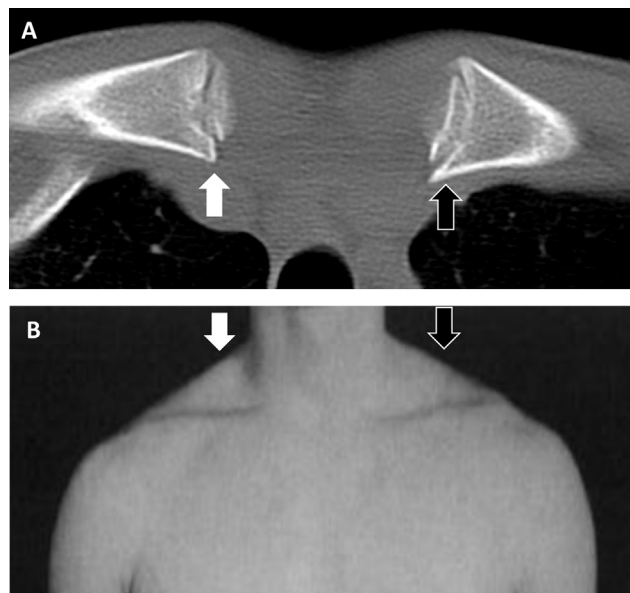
The locations of the right (white arrow) and left (black arrow) clavicular physes are shown on an axial computed tomography scan of a 15-year-old female patient (A). The clinical correlate (B) depicts a slight asymmetry noted after radiation therapy to a total dose of 15 Gy to the entire right clavicle (white arrow) and partial left clavicle (black arrow) in a male patient, resulting in mild clavicular narrowing and soft tissue asymmetry in the region of the right clavicle. Figure 5B is reprinted with permission from Merchant TE, Nguyen L, Nguyen D, et al.,⁴ with the only modification being the addition of the corresponding white and black arrows.
